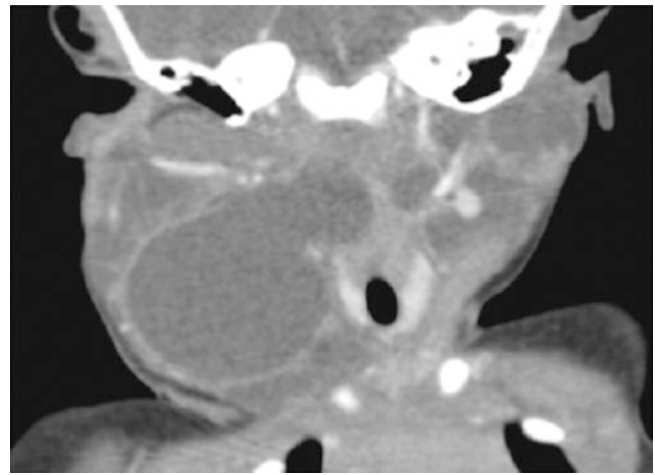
3-month-old girl who presented with palpable bilateral neck masses, right side greater than left side. Coronal enhanced reformatted CT image shows bilateral lymphatic malformation of the neck. The walls of the cystic spaces enhance with contrast while the centers (i.e., cystic portions) do not
